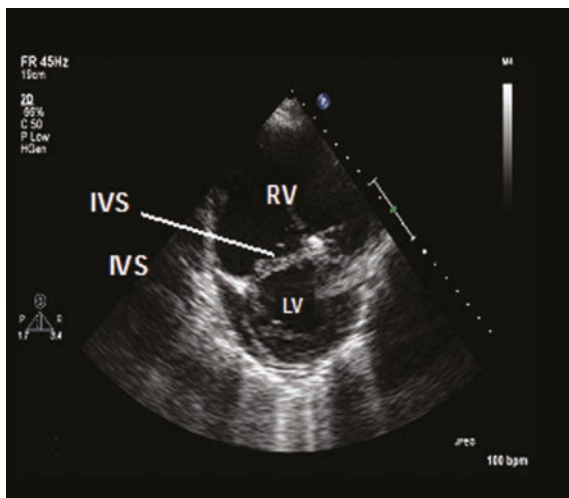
Short-axis view of a transthoracic echocardiogram in a patient with acute pulmonary hypertension having acute dilatation of the right ventricle (RV) compressing the interventricular septum (IVS) and left ventricle (LV). Courtesy of Dr Susanna Price, Royal Brompton Hospital, London, UK.
